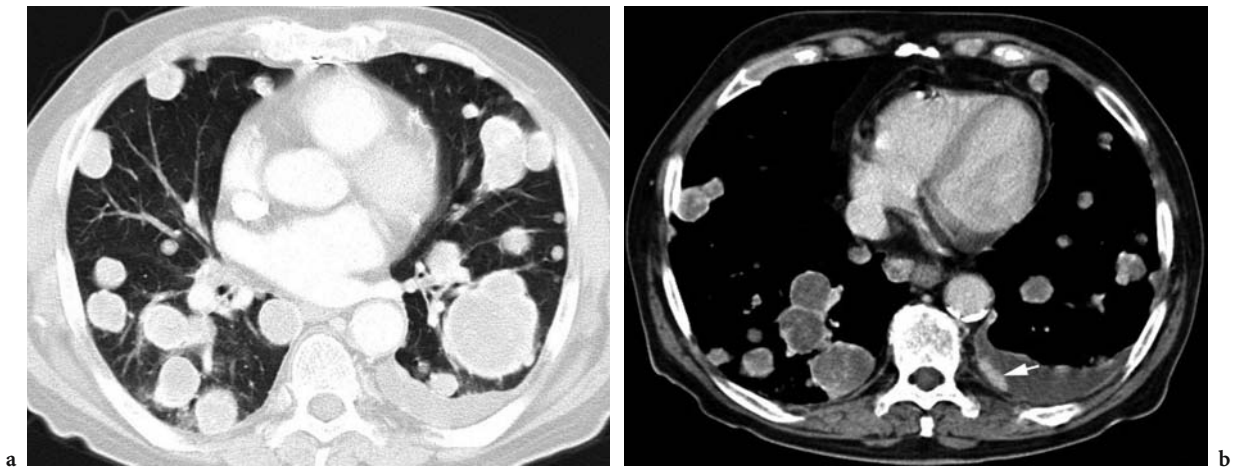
Lung and pleural metastases in a 67-year-old man who underwent nephrectomy for renal cell carcinoma. a Axial CT scan shows several bilateral rounded and oval pulmonary nodules of different sizes. b Axial contrast-enhanced CT scan of the chest shows that the pulmonary lesions are enhancing peripherally. It also shows a strongly enhanced left pleural-based lesion (*arrow*) associated with left pleural effusion.
